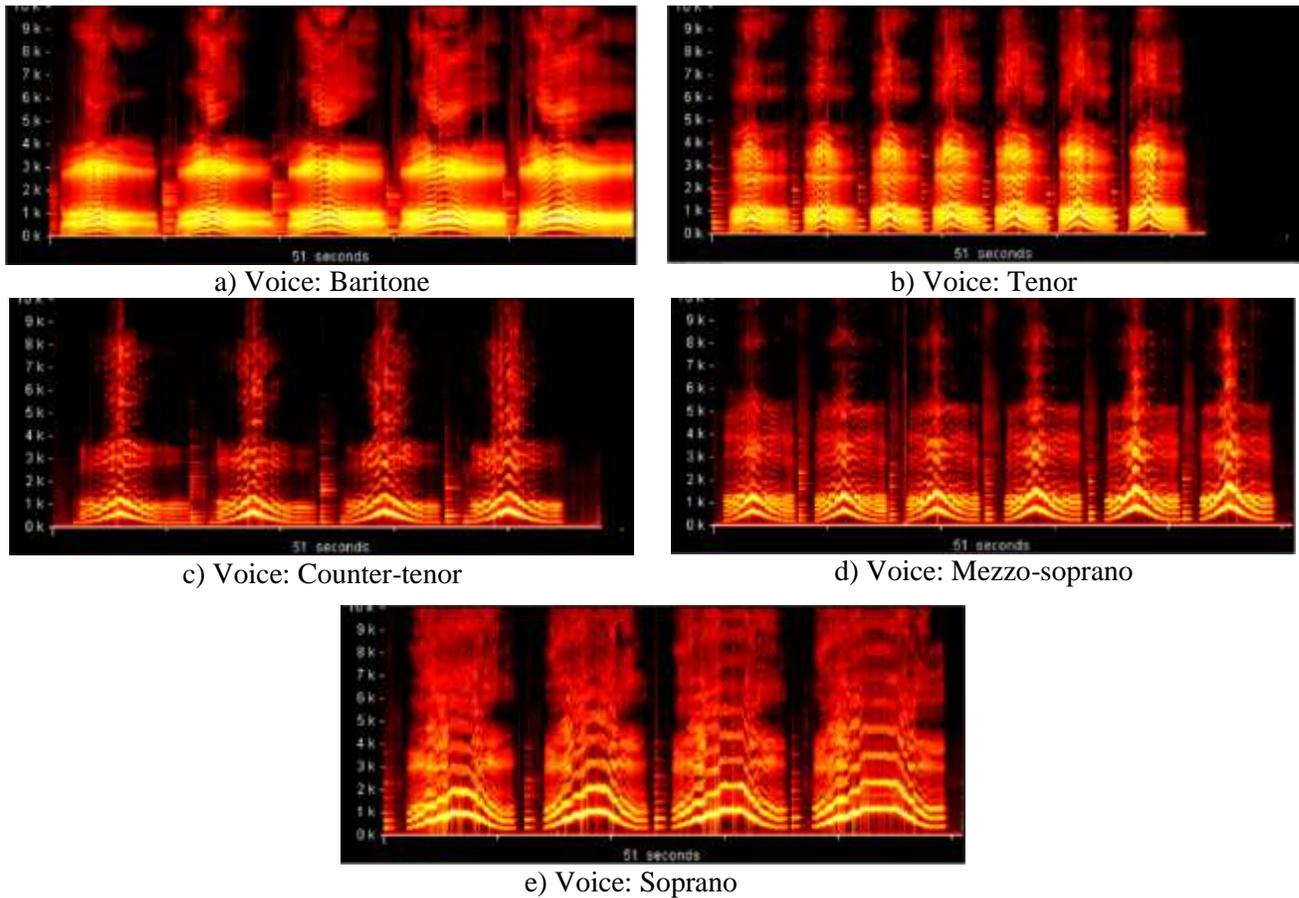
Sonogram. Grand Vocalise. (From [1])
